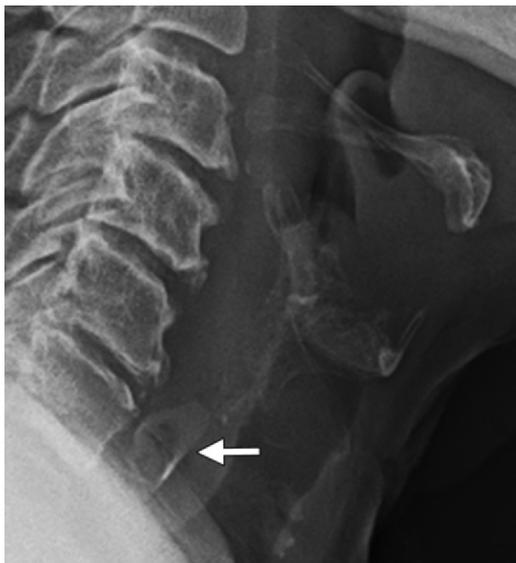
Ingested foreign body near the cricopharyngeus muscle in an 83-year-old woman with odynophagia after eating chicken. Lateral conventional radiograph of the neck shows a radiopaque foreign body (arrow) anterior to the C6 and C7 vertebral bodies. Upper gastrointestinal endoscopy revealed a bone fragment within the proximal esophagus just distal to the upper esophageal sphincter.
